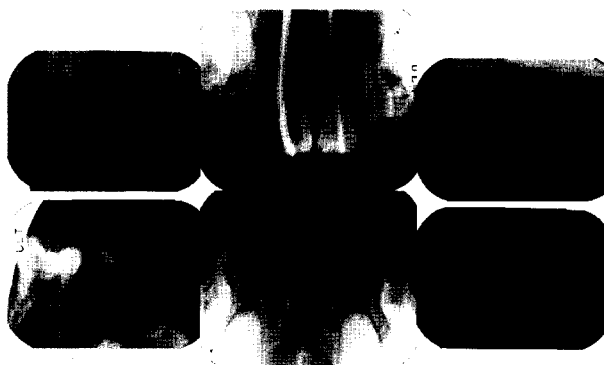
Pre-treatment intra-oral radiographs
